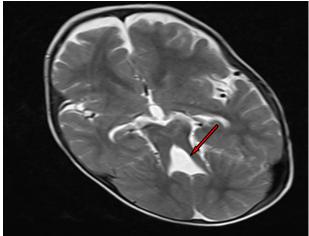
T2W axial MRI image showing molar tooth sign (arrow).
